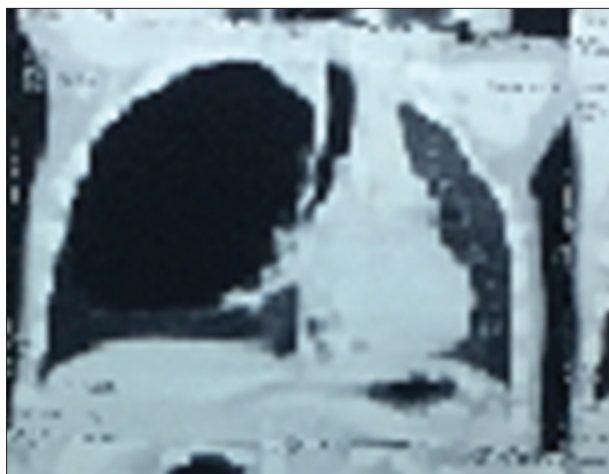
Contrast-enhanced computed tomography thorax - right-sided lung cyst
